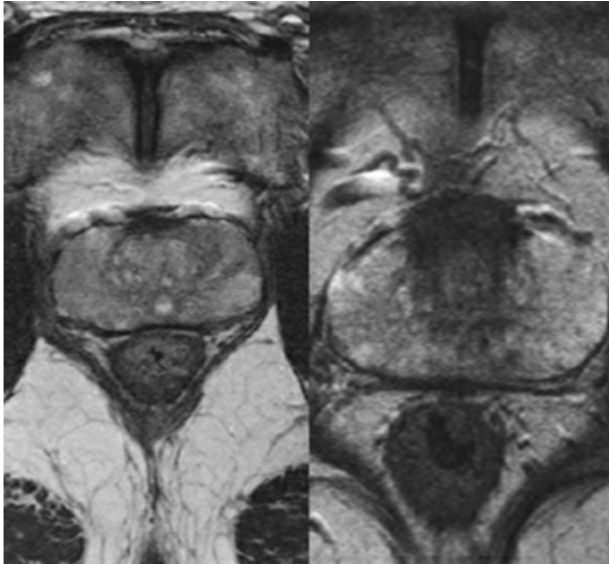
MRI (T1-image) showing focal lesions in the peripheral zone of prostate.
